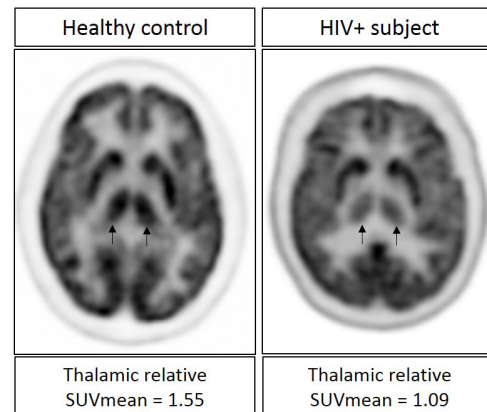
Qualitative comparison of thalamic FDG uptake (black arrows in both panels) compared to caudate and putamen uptake in a healthy control versus an age-matched HIV+ subject.
